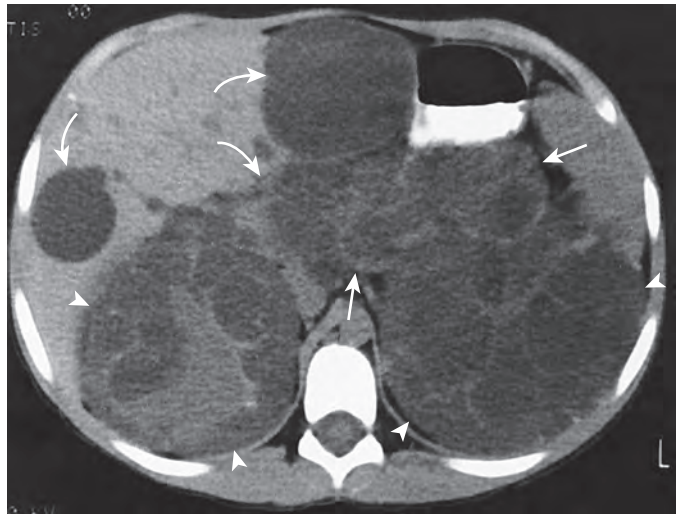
Pancreatic cysts in autosomal dominant polycystic kidney disease. The CT scan shows a pancreas (straight arrows) that is nearly replaced by large cysts in a 12-year-old boy with autosomal dominant polycystic kidney disease. The cysts also are demonstrated in the liver (curved arrows), and both kidneys are enlarged and contain many cysts (arrowheads).
